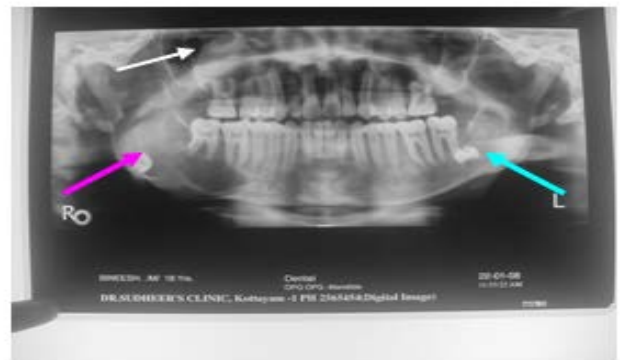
Orthopantomogram showing multiple cystic lesions
